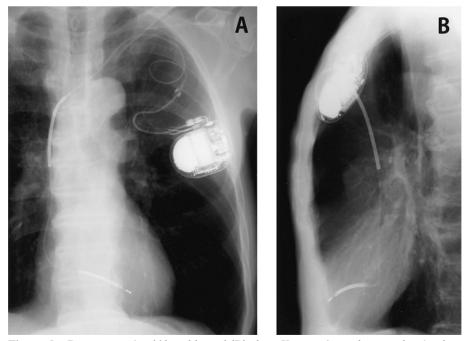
Posteroanterior (A) and lateral (B) chest X-rays after subpectoral re-implantation. The lateral view indicates that the device is located away from the skin.
